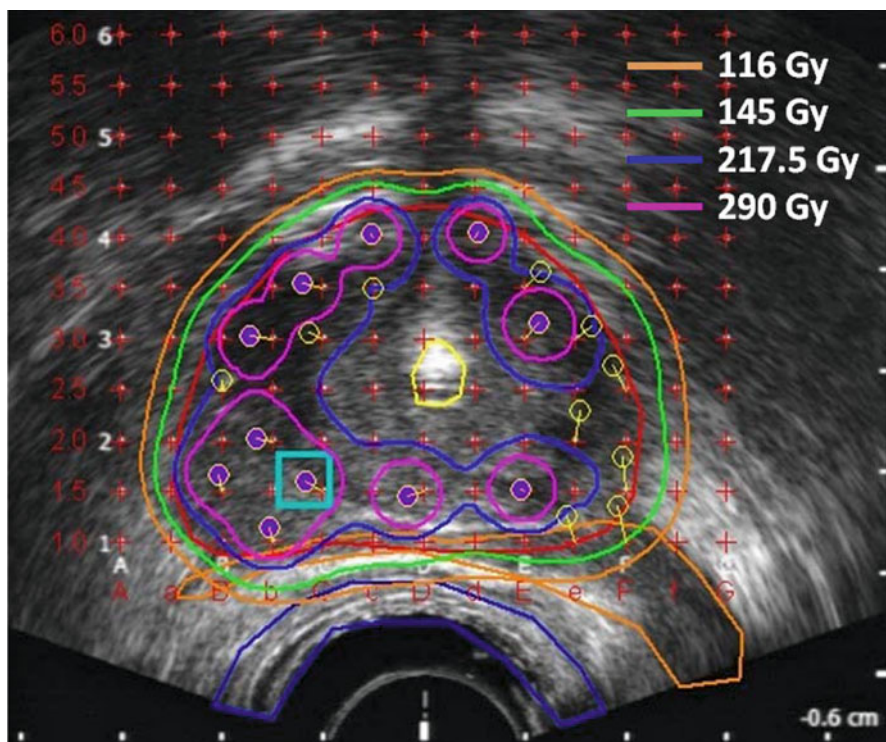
Transrectal ultrasound in transversal view. Prescription dose is 145 Gy (*green isodose line*). Needle paths are indicated by *yellow circles*, source positions by *purple filled circles*. The short *yellow lines* at the needle paths indicate the deviation of the needle path from the template coordinate position
